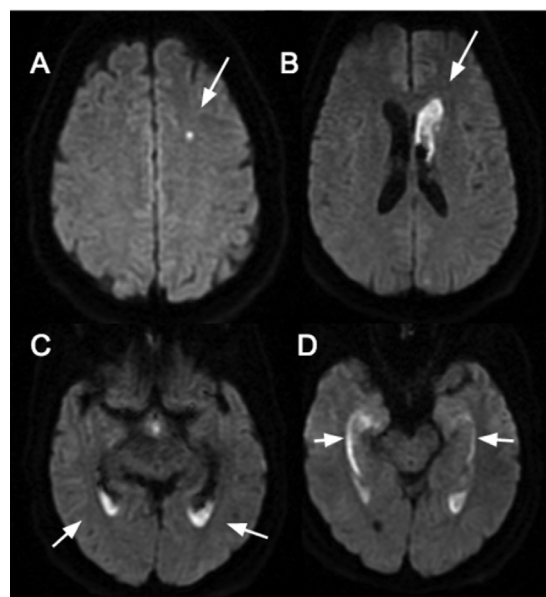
(a) Axial diffusion-weighted MR images demonstrating a focus of restricted diffusion in the left frontal lobe, most compatible with a microabscess. (b) diffusion-weighted imaging (DWI) signal abnormality is also seen within the frontal horn of the left lateral ventricle from intraventricular extension of a ruptured microabscess in the adjacent caudate lobe. Signal abnormality layers within the occipital (c) and temporal horns (d), compatible with ventriculitis.
